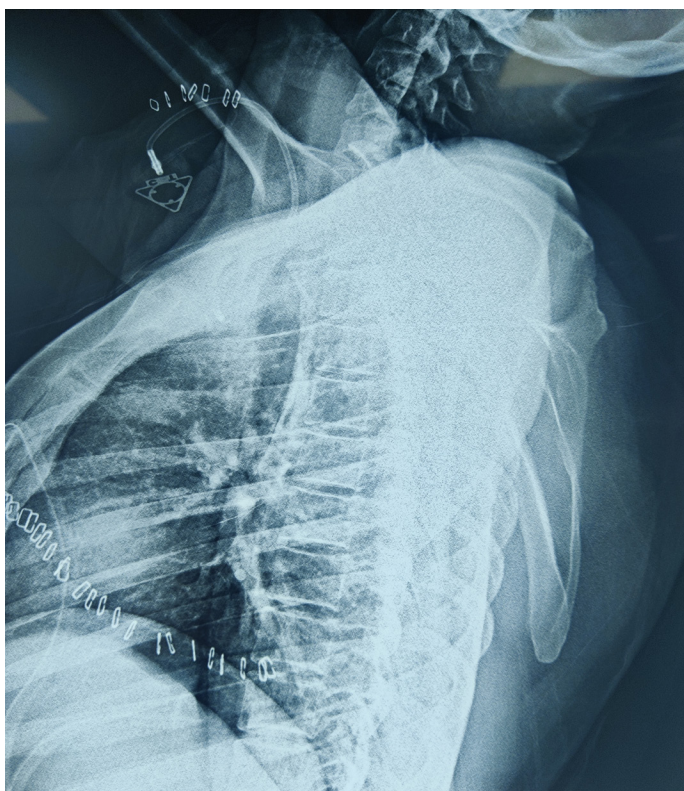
Post-operative lateral view of Chest X-ray confirming that the cephalic venous catheter has not extravasated into the surrounding tissue.
